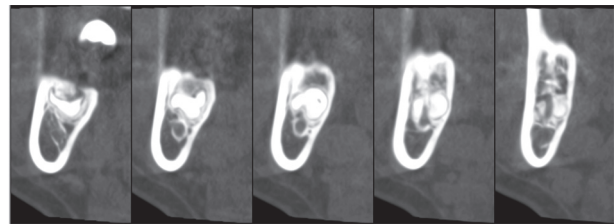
Control CBCT eight months after coronectomy. Axial view.
